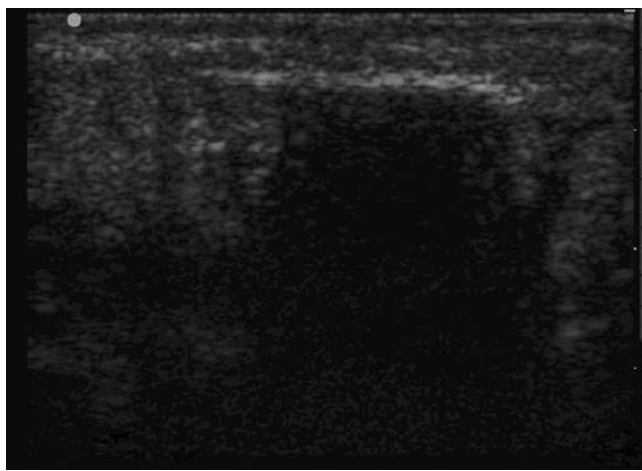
Bedside ultrasound was able to identify this toothpick in the foot of a pediatric patient, not identified by radiography. The hyperechoic toothpick is more obvious due to distal shadowing artifact.
